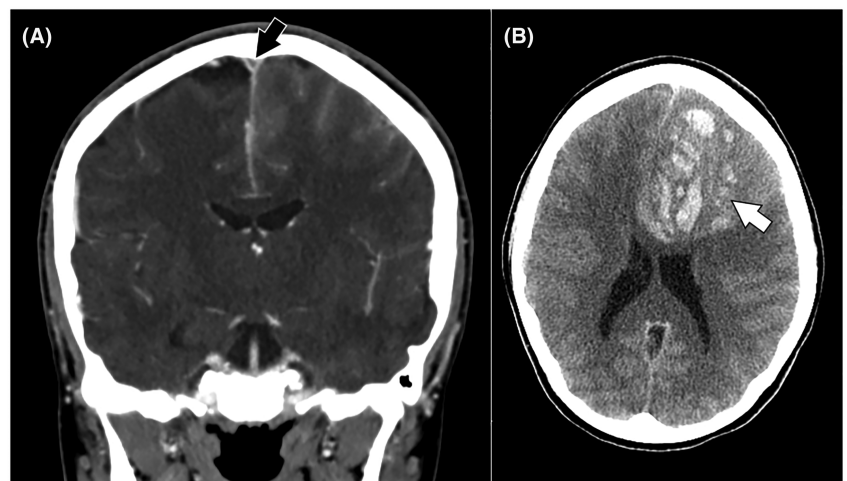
Imaging from patient 3. (A) A coronal section from the admission CT venogram, with a filling defect (“empty delta sign”) seen in the superior sagittal sinus (black arrow). An axial section from the unenhanced CT scan performed approximately 6 hours later (B) shows venous haemorrhage in the left frontal lobe (white arrow), with marked mass effect
